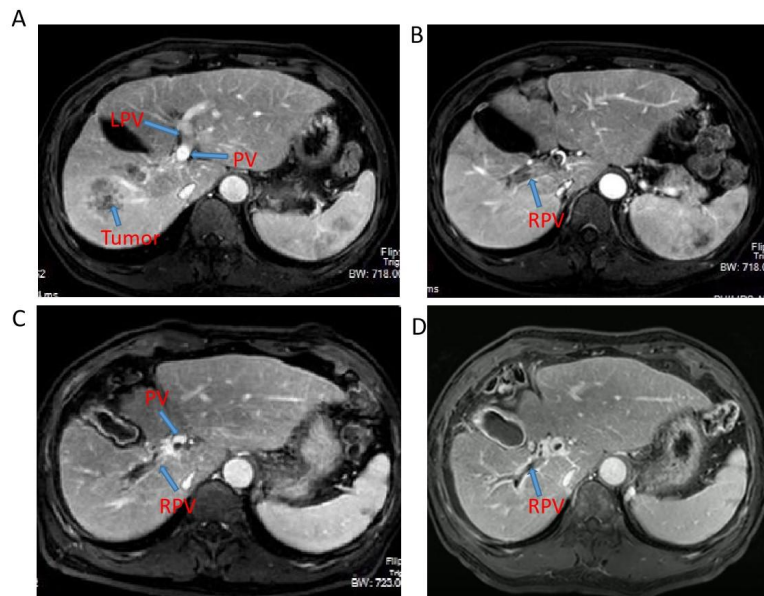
MRI examination at the initial treatment found that the tumor was located in the right liver, showing multi-nodule type, with obvious enhancement in arterial phase, accompanied by cancer thrombus in the main portal vein and right branch (A-B); After conversion therapy, the preoperative MRI showed tumor necrosis, weakened enhancement, obvious necrosis of portal vein tumor thrombus. The tumor thrombus in the main trunk regressed to the right branch (C-D). PV: portal vein. LPV: Left hepatic portal vein. RPV: Right hepatic portal vein.
